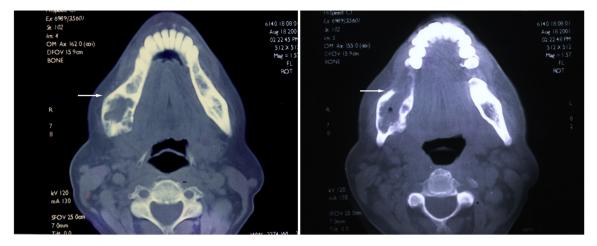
Preoperative CT scan showing expansion and perforation of the buccal cortex.
